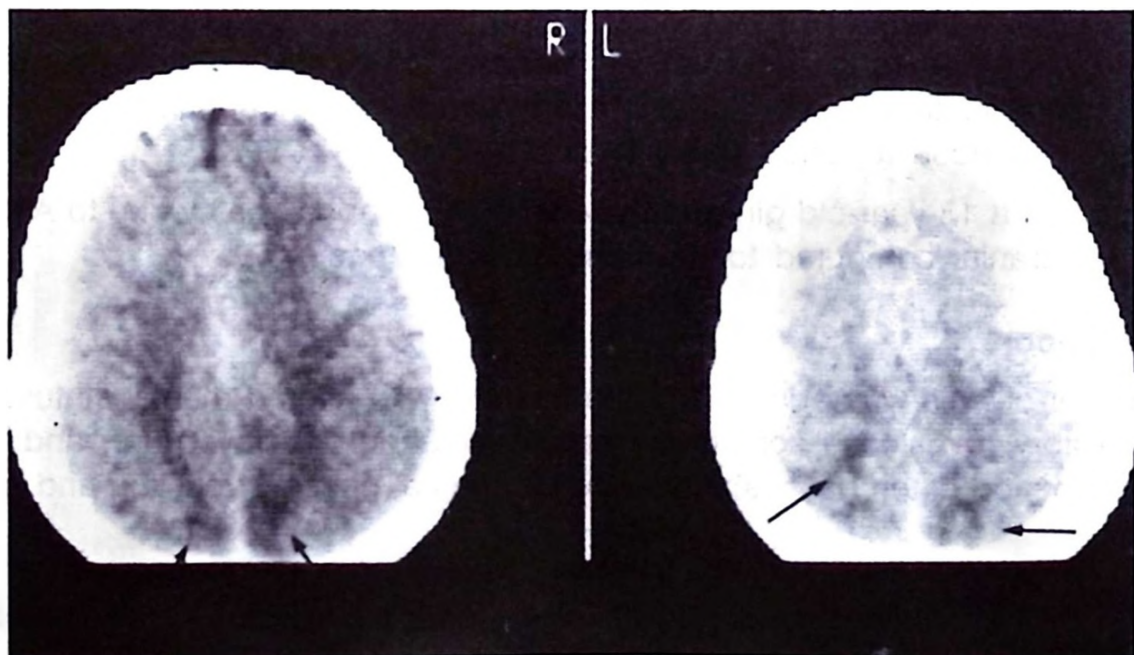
Contiguous axial non-contrast CT images reveal bilateral parieto-occipital areas with decreased attenuation, more obvious on the right side.
